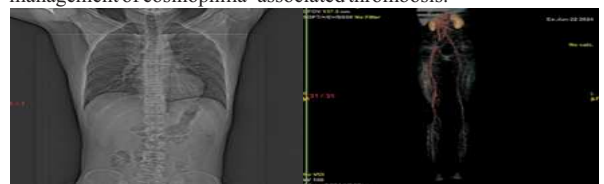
CT Venogram of the abdomen, pelvis, lower limbs: multiplanar reformatted images showing inferior vena cava with normal patency with near complete filling defect with enhancing wall noted in left common iliac vein extending to the left external and internal iliac vein, common femoral vein, extending into Great Saphenous Vein, superficial and deep femoral vein, popliteal vein, anterior tibial vein, posterior tibial veins.
